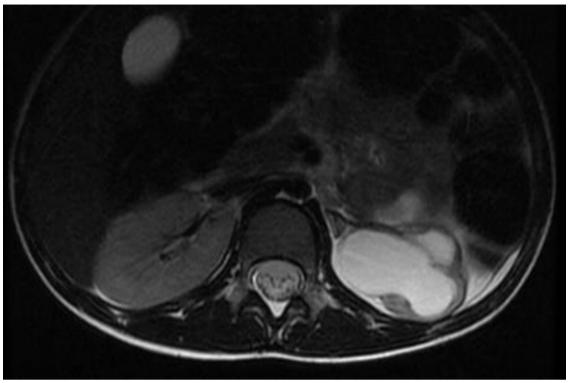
Axial T2-weighted MR image in the same patient showing left ureterohydronephrosis complicating neurogenic bladder (arrow)
